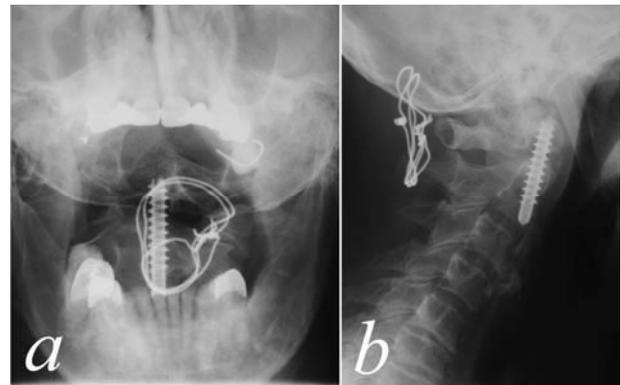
X-ray of type II dens fracture non-union managed with modified posterior occipitocervical fusion followed by direct odontoid screw fixation. a – front view; c – lateral view
